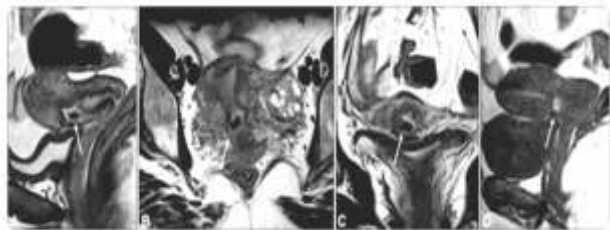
A, B, C: T1 weighted images of MRI; D: T2 weighted image of MRI
